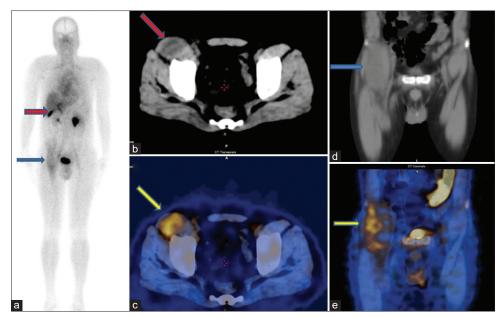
The whole body planar [a] image of Tc 99m ethambutol scintigraphy revealed a band of increased uptake in the right lower abdomen, pelvis, and upper thigh (blue arrow) and physiological uptake in the gall bladder (red arrow). Axial and coronal CT and fused SPECT/CT images [b-e] show an abscess with heterogeneous increased tracer uptake in the right iliopsoas (arrows) respectively
